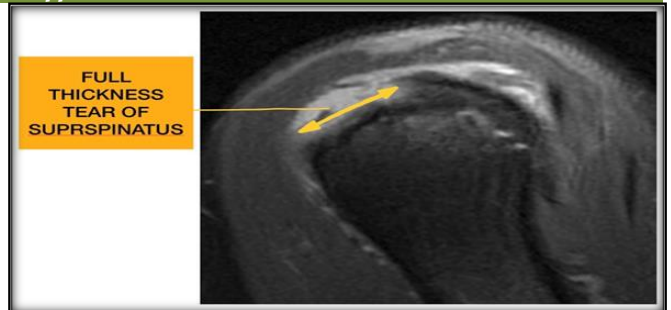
A 40 year old female with difficulty in lifting her arm, diagnosed to have full thickness tear of supraspinatus tendon. Image - MRI- T2 weighted fat suppressed Image, sagittal section showing a full thickness tear of supraspinatus tendon. Double headed arrow showing the diameter of tear.
